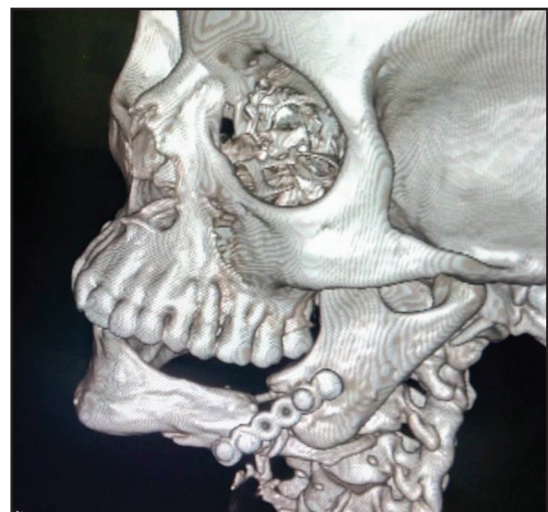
Postoperative CT after transportation Distraction osteogenesis.
